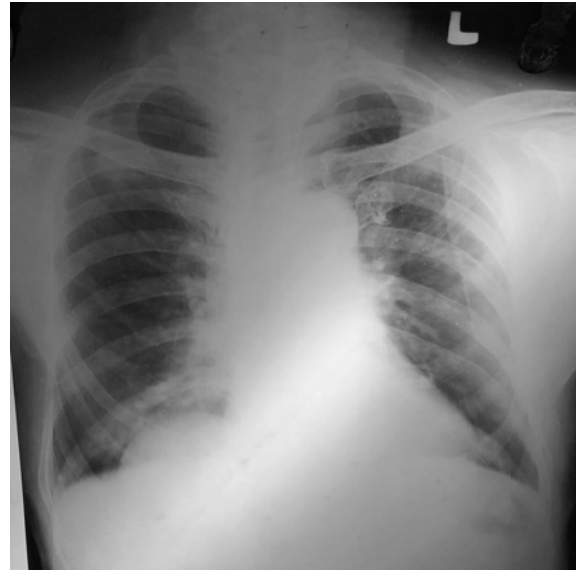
Chest X-Ray showed opacity over base of right lung
